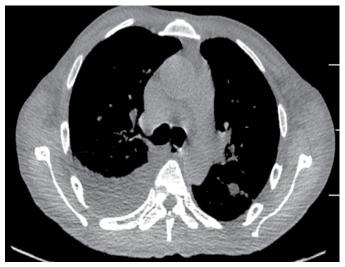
Non-enhanced chest computed tomography scan showing unilateral right sided pleural effusion with small mediastinal right-sided lymphadenopathy and cardiomegaly.
